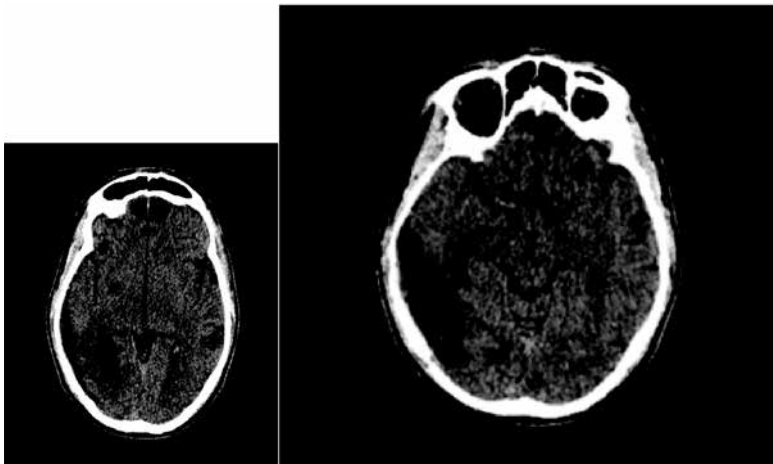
and 3B. CT of the head 2.5 months from the trauma performed with a 64-slice CT DISCOVERY EVO CT 750 HG GE MEDICAL SYSTEMS, 120 kV, 280 mA, images on the transverse plane, slice thickness 0.625 mm. Midbrain haematomas, subdural haematoma, blood in the brain fissures and intracranial gas receded. Secondary post-traumatic changes appeared in the form of post-haemorrhagic cavities, dilation of pericerebral spaces and asymmetric dilation of the ventricular system. Cranial bones fractures healed.
